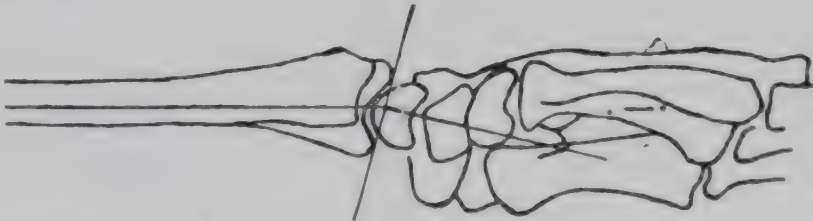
Angle of articular surface, lower end of radius. (Sante, L. R.: Manual of Roentgenological Technique, Edwards Brothers.)
